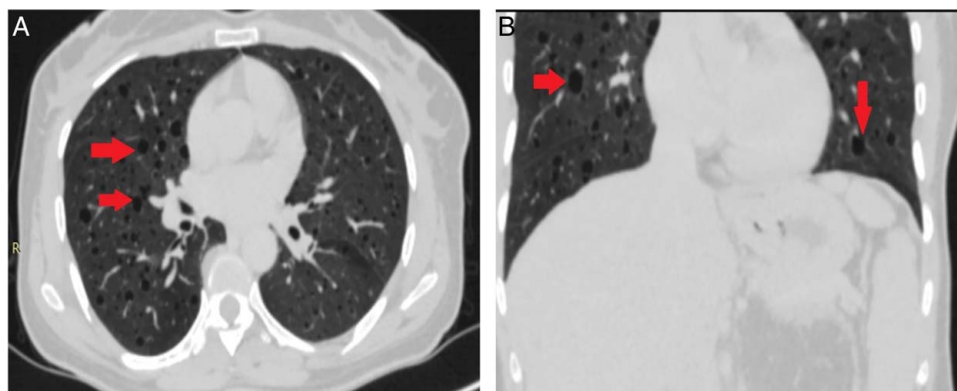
High-resolution computed tomography images in the axial plane (A), and coronal plane (B) shows multiple round thin-walled cystic lesions in random distribution in bilateral lungs. These findings are consistent with lymphangioleiomyomatosis.
